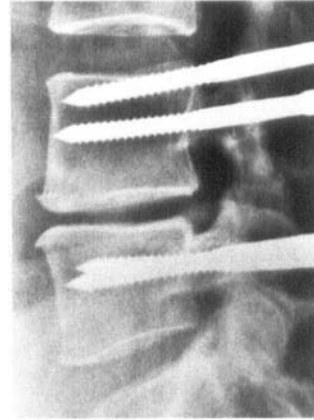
The lateral radiograph reveals a Schanz screw lying cranial to the pedicle. The patient had no neurological deficit and was painfree during the test.
